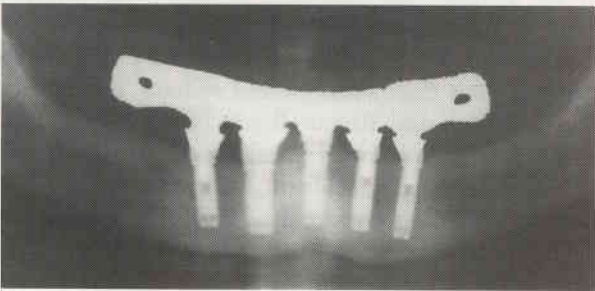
Postprosthesis placement radiograph of patient 10 showing all five implants incorporated into the final prosthesis.
